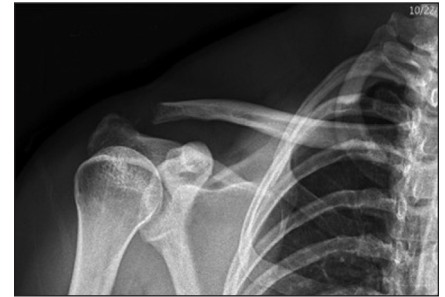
Postoperative Zanca radiograph showing adequate decompression of the acromioclavicular joint.
